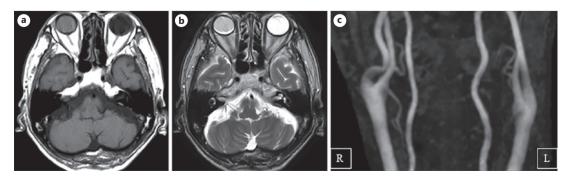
MRI findings. a, b MRI showed no abnormal findings in the brain or around the orbit. c 3D-MRI showed no stenosis or aneurysm in the internal carotid artery or ophthalmic artery. MRI, magnetic resonance imaging.
